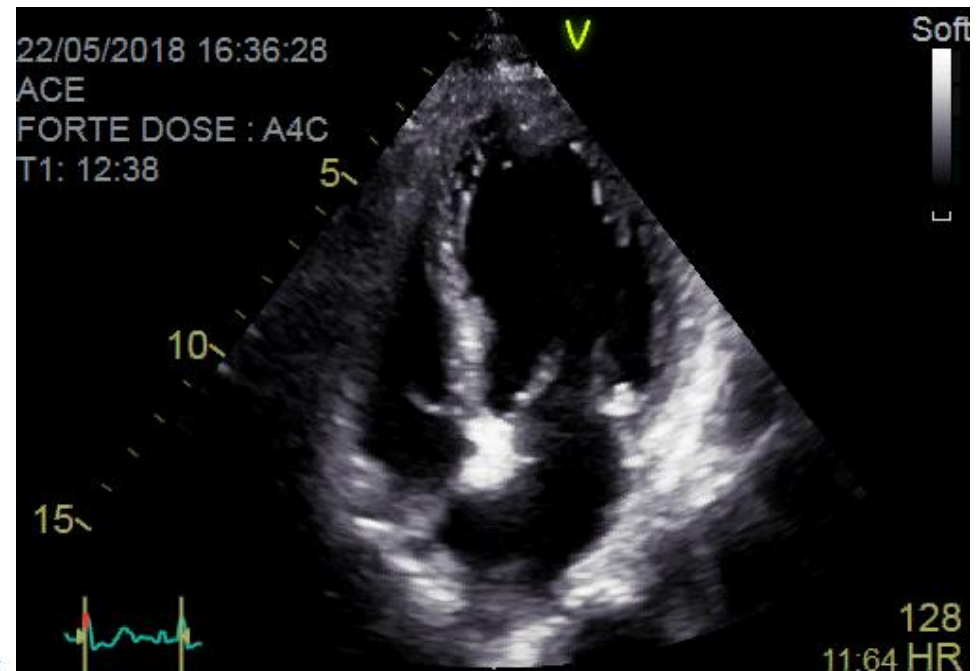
Exercise echocardiography: four-chamber view at rest (A) and at peak exercise (end-systole) (B). The characteristic RA-HA sign is observed at peak stress with lateral motion of the apex towards the right.
